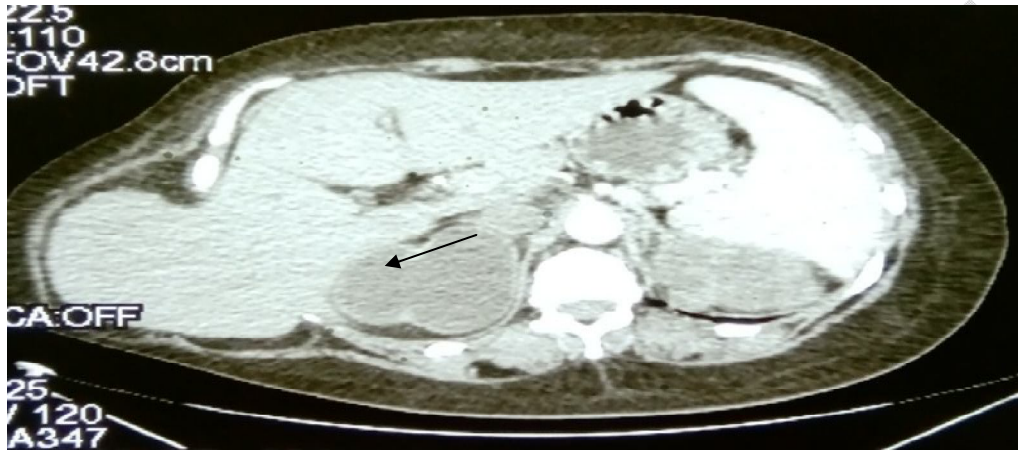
CT scan showed a giant lumbar hernia of right liver (arrow)
